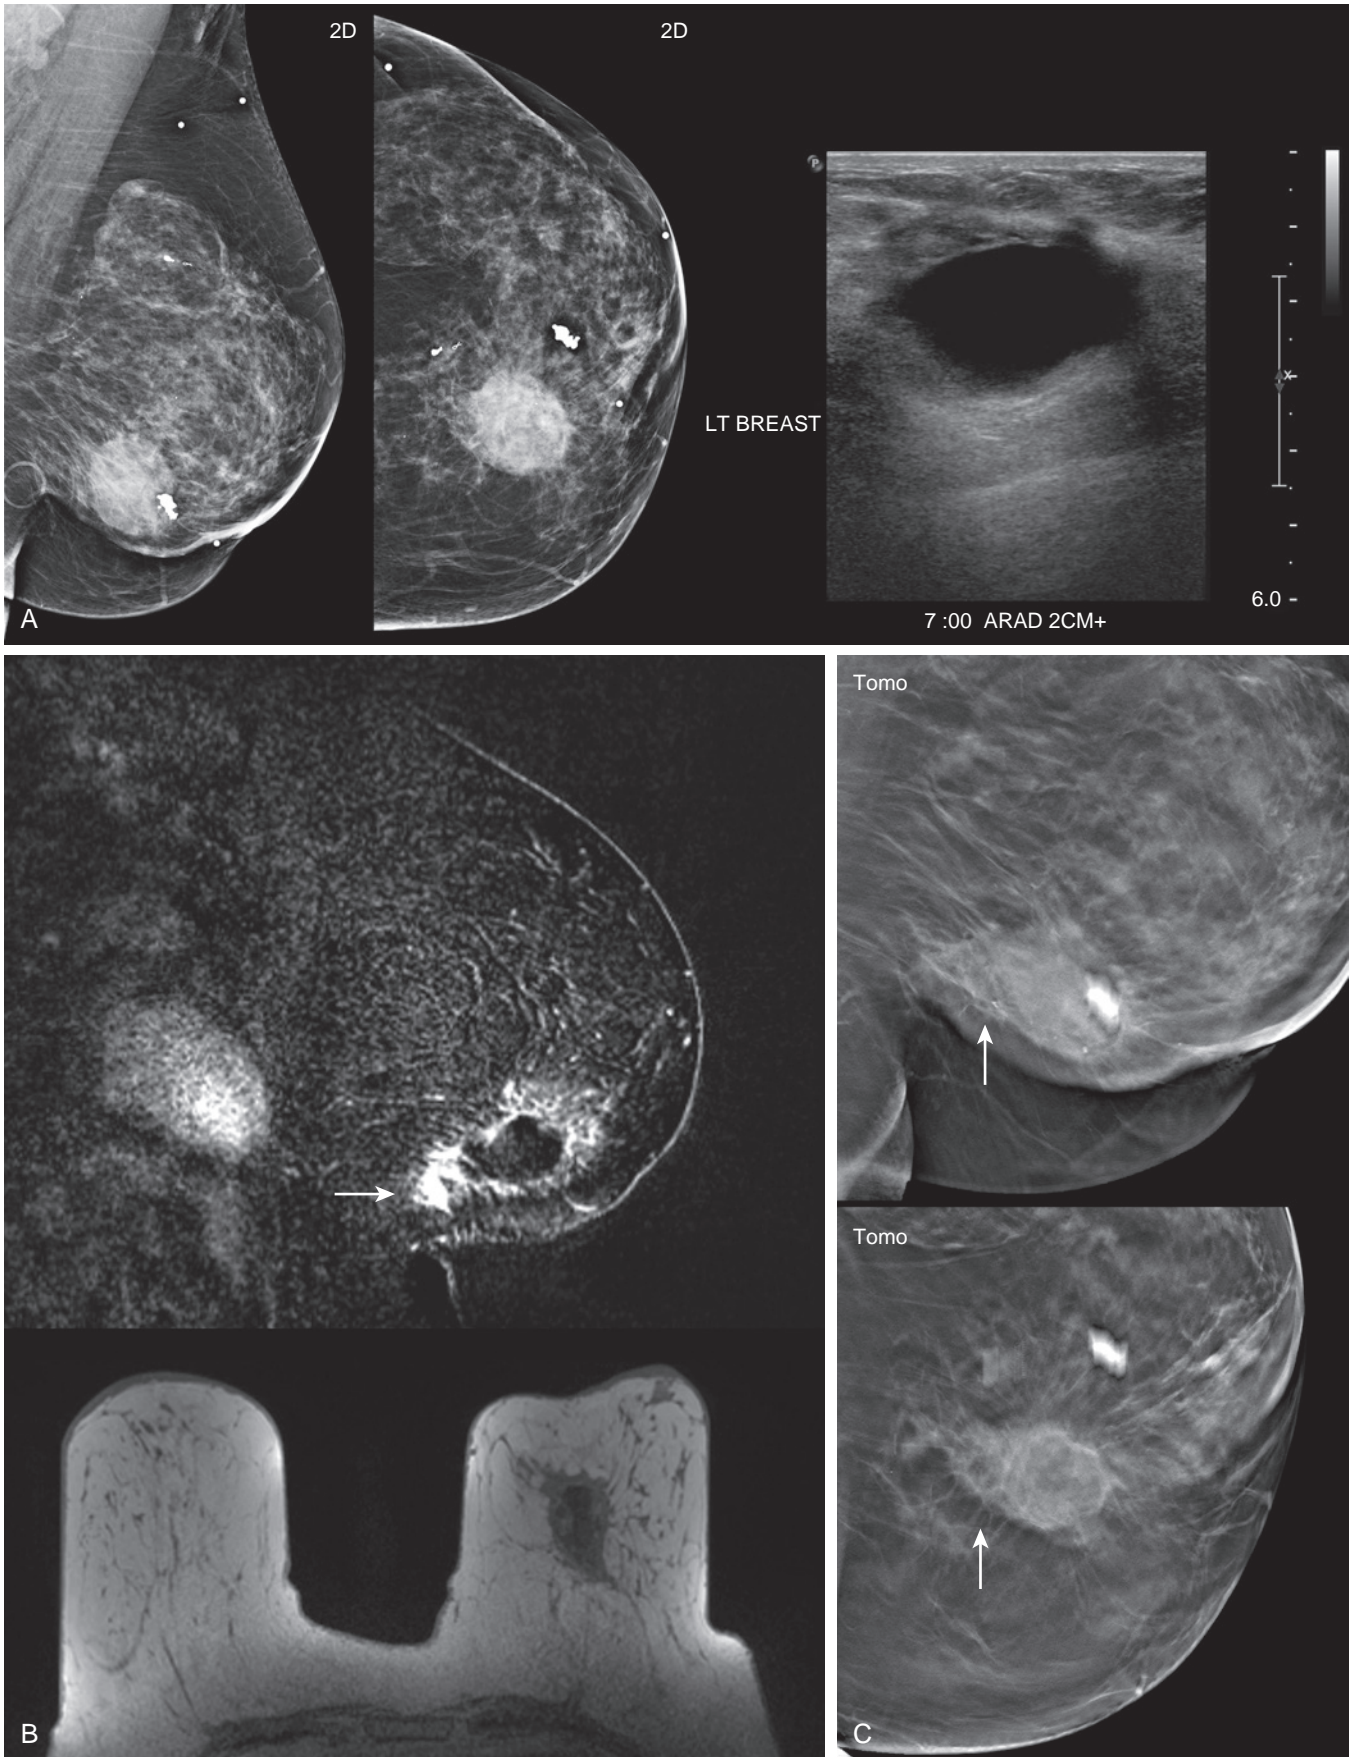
Fat necrosis. (A) Three years following lumpectomy and partial-breast irradiation (balloon catheter) for invasive lobular carcinoma, a routine mammogram and ultrasound on a 69-year-old woman show a seroma and otherwise normal posttreatment changes. (B) Six years following treatment a screening magnetic resonance imaging shows new suspicious mass enhancement (*arrow*) with washout kinetics (not shown) along the posterior aspect of the seroma. Fat is not evident within the lesion on the precontrast non-fat-saturated T1 sequence. (C) However, mediolateral oblique and craniocaudal tomosynthesis slices show oval lucencies within a corresponding new indistinct asymmetry (*arrows*). Ultrasound-guided biopsy reveals benign fat necrosis.
